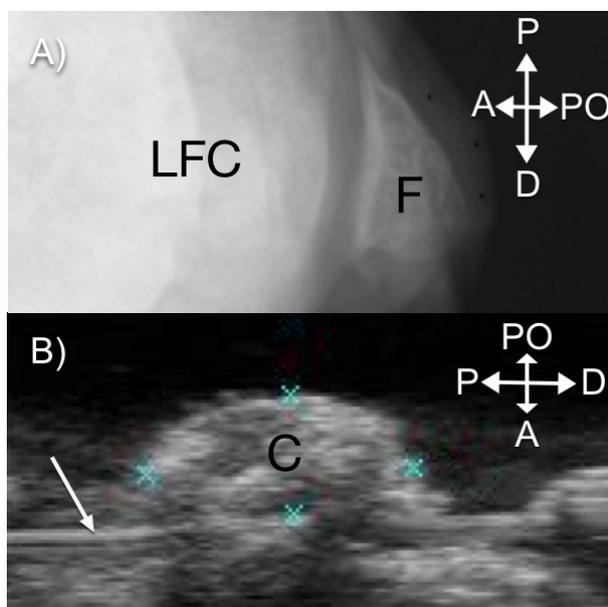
Radiography and ultrasound images of the fabella and cyamella *in situ* respectively. A) Lateral view of a knee showing the fabella (F) posterior to the lateral femoral condyle (LFC) within the tendon of the lateral head of the gastrocnemius muscle. It has a convex posterior surface and a flat anterior articular surface; B) Posterolateral view of the first cyamella. A needle (white arrow) inserted anterior to the cyamella (C) shows that the cyamella is not an attachment of the bone or the meniscus. P= proximal; D= distal; PO= posterior; A= anterior.
